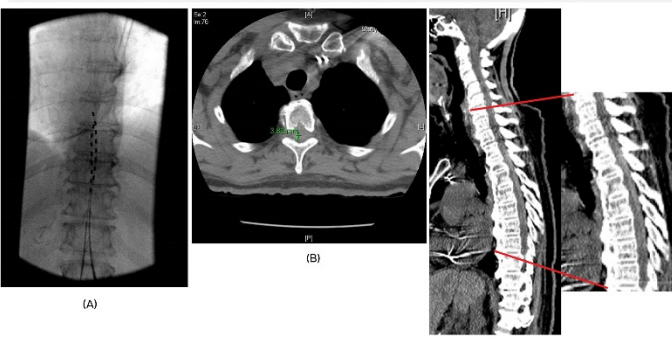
a) Radiograph of thoracolumbar spine showing SCS electrode tips at the T8-9 interspace, b) axial CT of the mid thoracic spine demonstrating blood in the epidural space, and c) sagittal CT with T2-T9 epidural hematoma.
